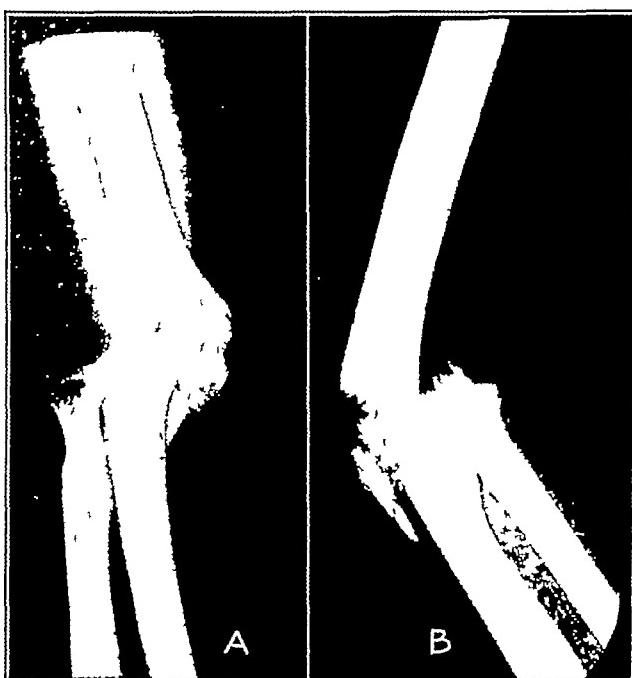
(case 5).—*A*, anteroposterior and, *B*, lateral roentgenograms of left elbow taken four months following sideswipe fracture. There is a persistent dislocation of the elbow joint, with loss of the major portion of the lateral humeral condyle and a nonunion of the small remaining fragment of the olecranon. Despite the pronounced disorganization of the joint, there is a satisfactory range of painless motion.
